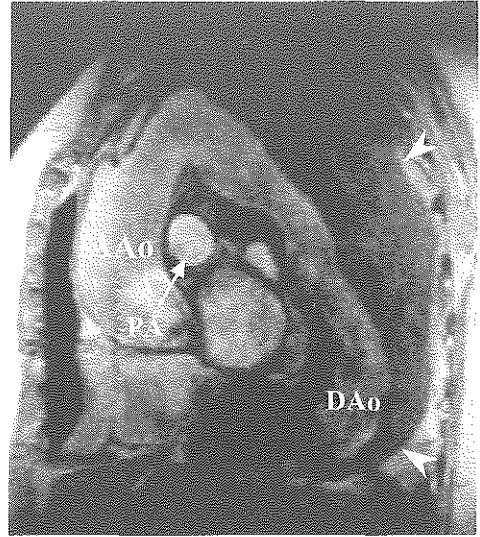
Example of gradient echo MR imaging in patient with an aneurysm of the descending aorta (DAo). With this technique blood will appear bright in the images, although slow flowing blood may be saturated and have the same intensity as thrombus (arrowheads). Reviewing the images from different phases of the cardiac cycle allows differentiation of slow flowing blood from mural thrombus. Same patients as in figure 2, using a slightly different slice position.
